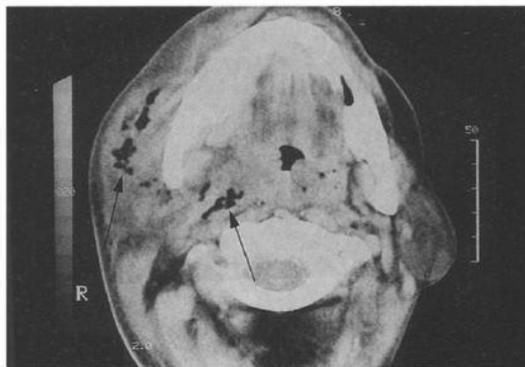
(Patient 5) Precontrast CT scan at level of body of mandible, showing swelling of right parapharyngeal and submandibular region and gas bubbles within it (arrows).
